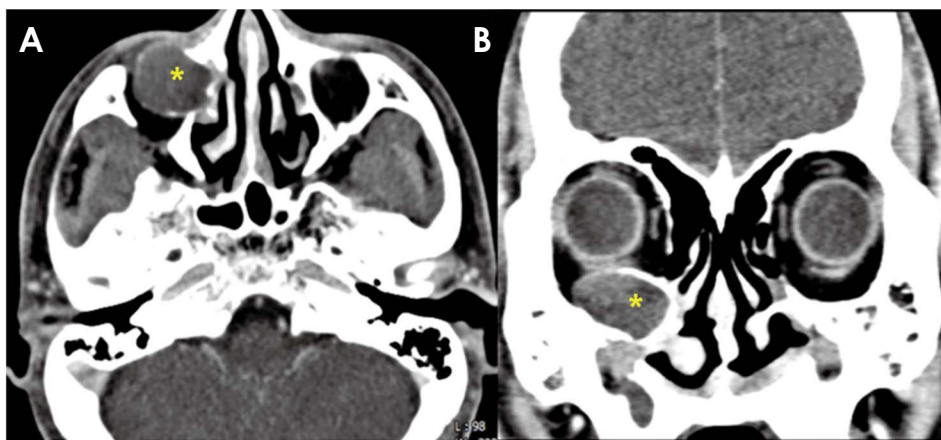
A. An axial computed tomographic image (second visit) shows a well-defined, enlarged multilocular cystic lesion extending superiorly to the orbit (asterisk). The Hounsfield units inside the lesion are similar to those of fluid but not soft tissue, indicating that the lesion is filled with fluid. B. A coronal computed tomography image shows erosion of the right orbital floor and displacement of the right eyeball.
